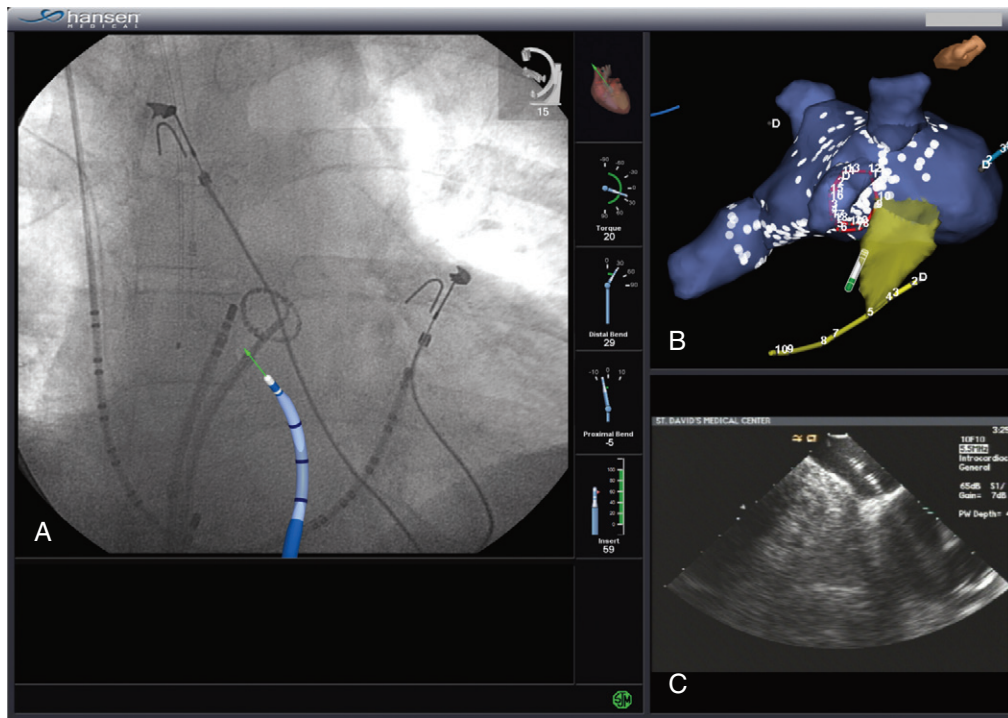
Posterior wall isolation using the Sensei (Hansen Medical) robotic system. A, Fluoroscopy image showing the virtual catheter and the real Artisan (Hansen Medical) catheter at the level of the posterior wall guided by the circular mapping catheter. B, EnSite NavX (St Jude Medical, Inc.) map obtained during the procedure showing ablation (white dots). C, Intracardiac echocardiography image obtained during the procedure showing the Artisan catheter in the posterior wall.
